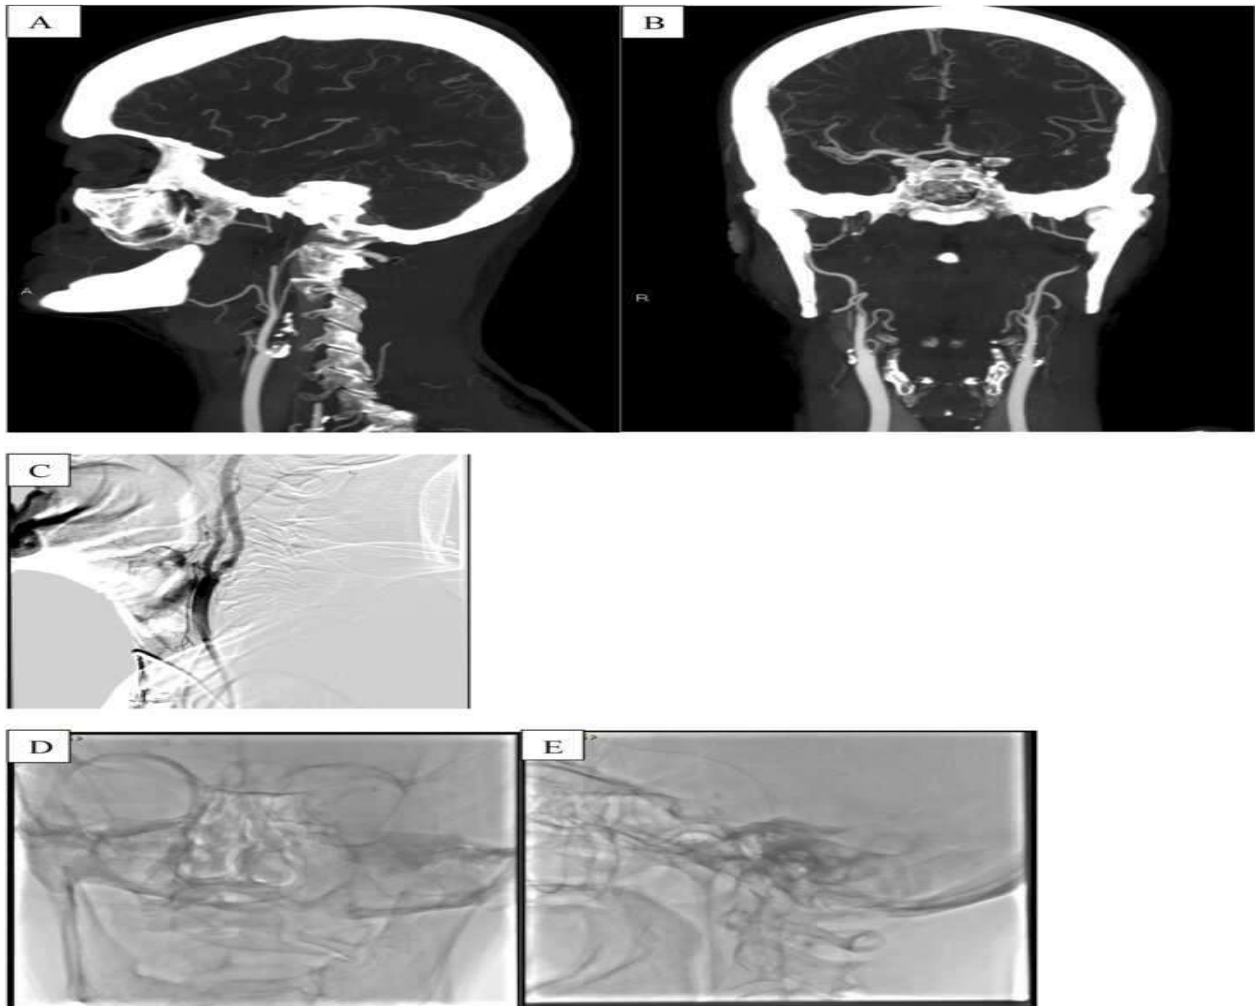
Angio-CT (A-B) showed tandem occlusion of left proximal internal carotid artery+occlusion of M1 tract of MCA. Dilatation with angioplastic balloon, without deployment of carotid stent, was performed (C), in order to cross extracranial lesion. After two attempts of thromboaspiration, complete recanalization, TICI 3, of the intracranial circulation was obtained (D-E) [19].
